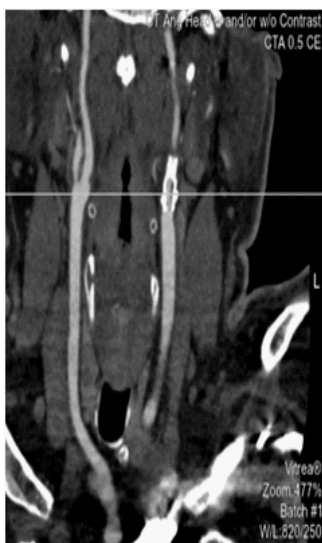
CTA shows acute left internal carotid stenosis. Stent visualized in-situ.
